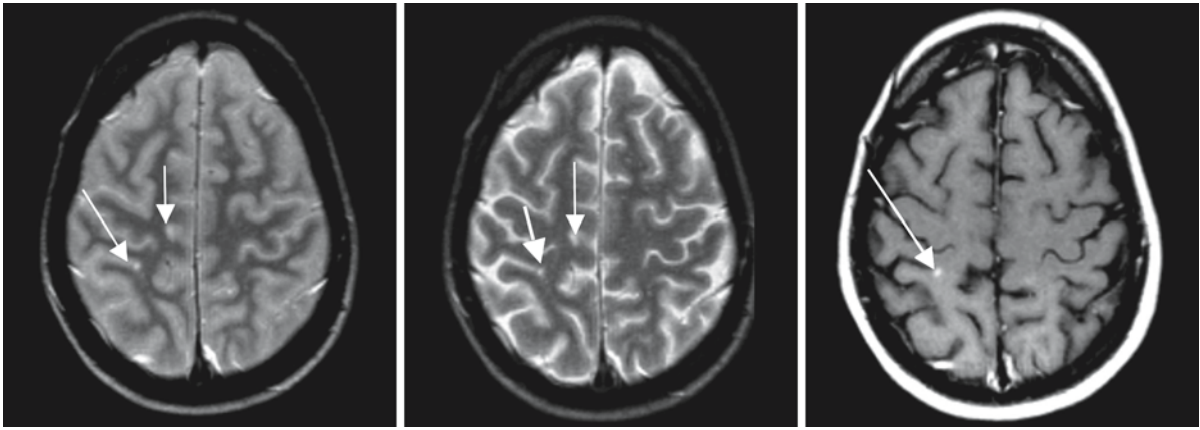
Juxtacortical lesions are important in a definite diagnosis of MS, but can be difficult to identify on MR images. In this series of three transverse images tiny lesions are noted
